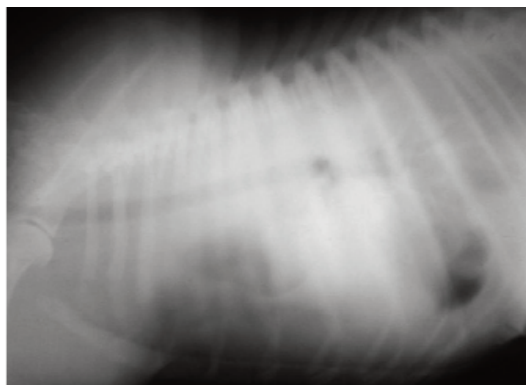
Lateral thoracic radiograph taken during initial examination (the day referred) shows the radiopaque appearance of thorax and loss of cardiac silhouette resulting from pleural fluid.
